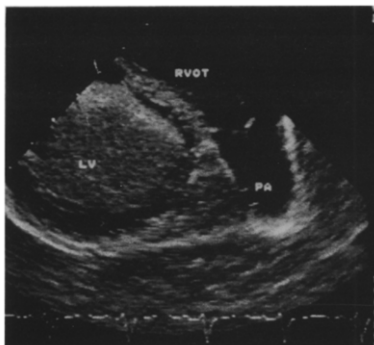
Contrast echocardiographic study in the right ventricular outflow long-axis view. The left ventricle (LV) is cut in short axis and the right ventricular outflow tract (RVOT) and the main pulmonary artery (PA) in long axis. With use of this view, the definite exclusion of residual left to right shunting, as in this patient, can be made with a single injection of contrast medium into the left atrial line.
